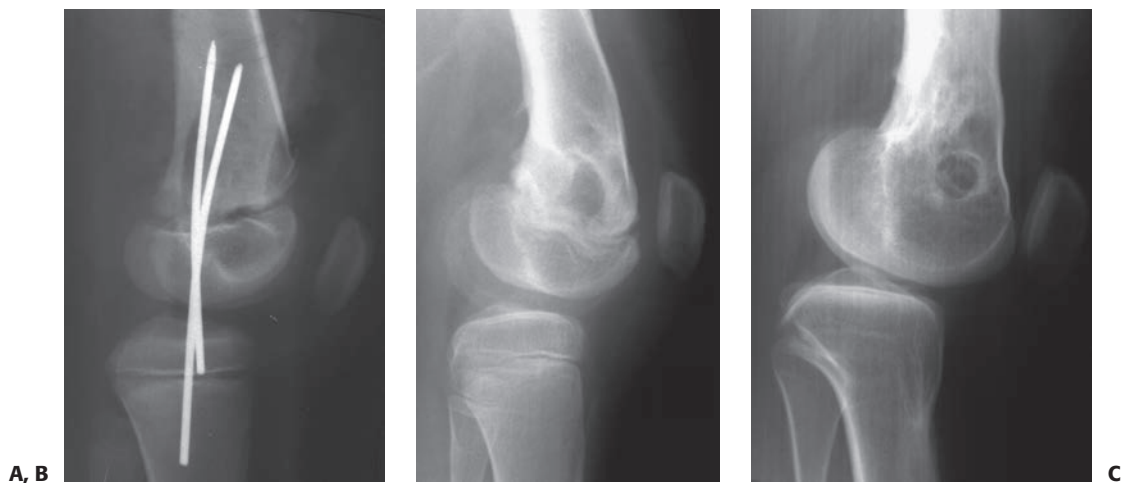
Posttraumatic closure of the anterior proximal tibial physis after displaced Salter–Harris type II fracture of the distal femoral physis. A: Lateral radiographs after reduction. No injury to the proximal tibia was noted at the time of treatment of the distal femoral injury. B: At follow-up, distal femoral physeal growth disturbance with flexion deformity is apparent. C: At skeletal maturity, proximal tibial extension deformity with sclerosis of the tibial tubercle area is evident, suggestive of arrest in this area. The patient has undergone a distal femoral extension osteotomy.
